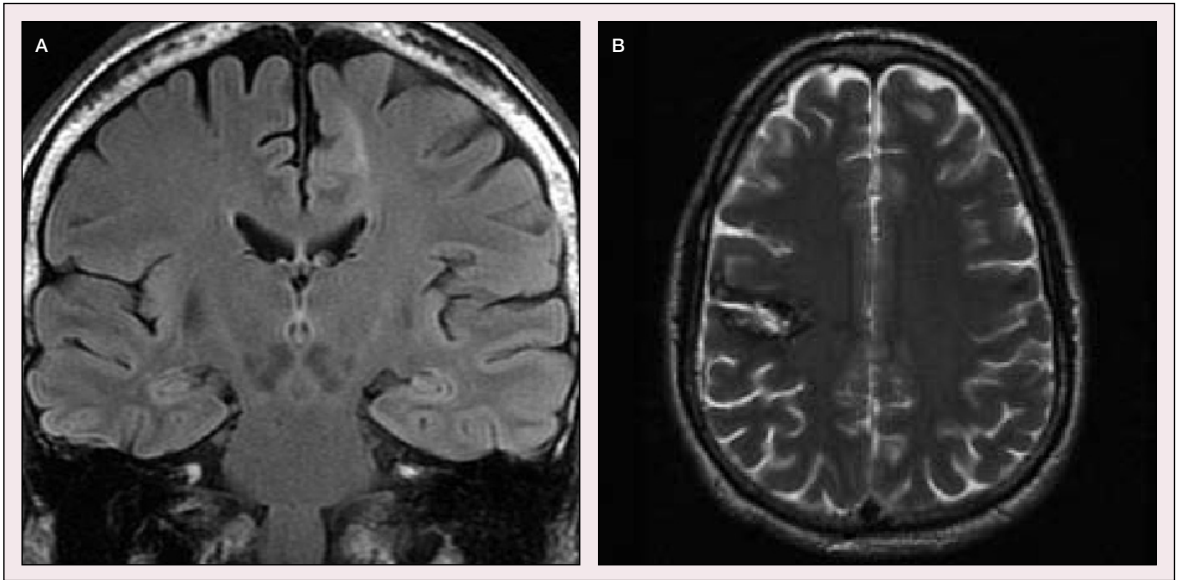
(A) Coronal FLAIR MRI showing focal cortical dysplasia in the supplementary motor area of the left frontal lobe. Note the tail extending down towards the frontal horn of the lateral ventricle. This patient was 60 years old and had experienced left SMA seizures for 7 years. All previous MRI studies were negative. (B) Axial T2-weighted MRI showing a heterogeneous lesion in the left precentral area. The signal changes are consistent with haemosiderosis suggestive of a cavernous angioma. *Figure A* courtesy of Professor John S Duncan and the National Society for Epilepsy MRI Unit, London, UK. *Figure B* courtesy of Dr Ruben Kuzniecky, NYU Epilepsy Center, New York, USA.
